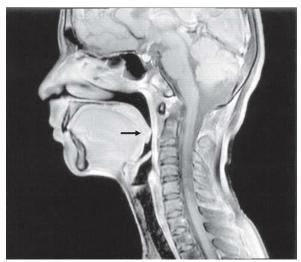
MRI demonstrating reduced anteroposterior diameter at retro-palatal level
